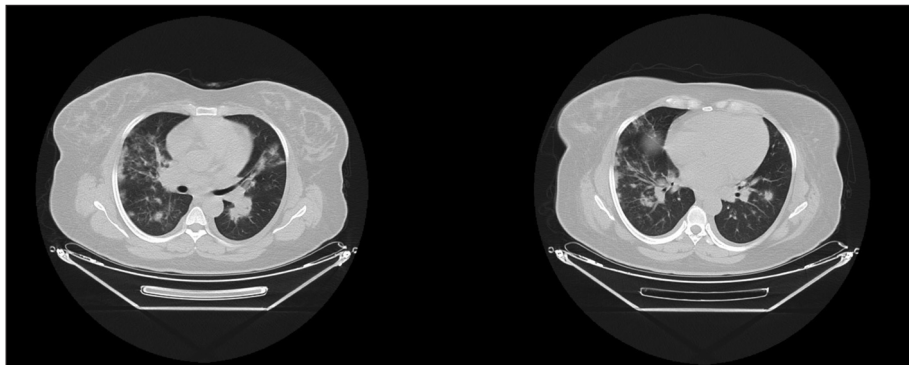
Initial chest computed tomography scan on the postoperative first day.
